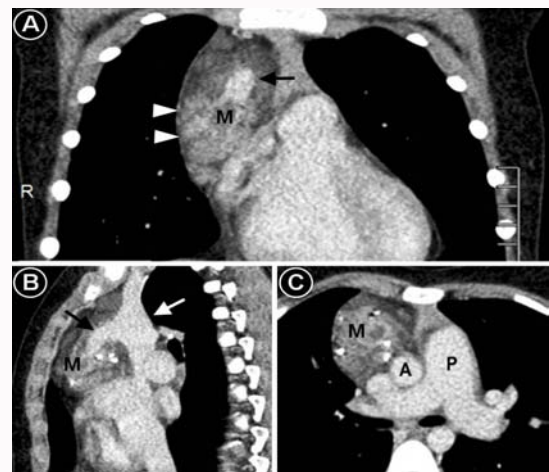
Venous phase of contrast enhanced computed tomography showing puddles of heterogeneous enhancement (arrowheads) within the mediastinal mass with a better visualization compared to arterial phase. A large vein in the center of the mass (pointed by a black arrow) is draining into superior vena cavae (pointed by a white arrow). The pulmonary artery (P) appears prominently dilated compared to ascending aorta (A). Panel A – coronal view, panel B – sagittal view, panel C – axial view.
